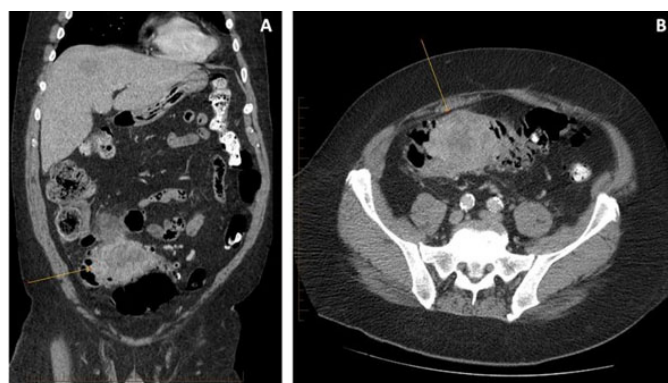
CT with contrast of the abdomen and pelvis showing large sigmoid mass. Coronal (A) and axial (B) images showing a large sigmoid mass approximately  $7 \times 5.2$  cm as well as a 4.8 cm lesion in the liver segment 7/8.
